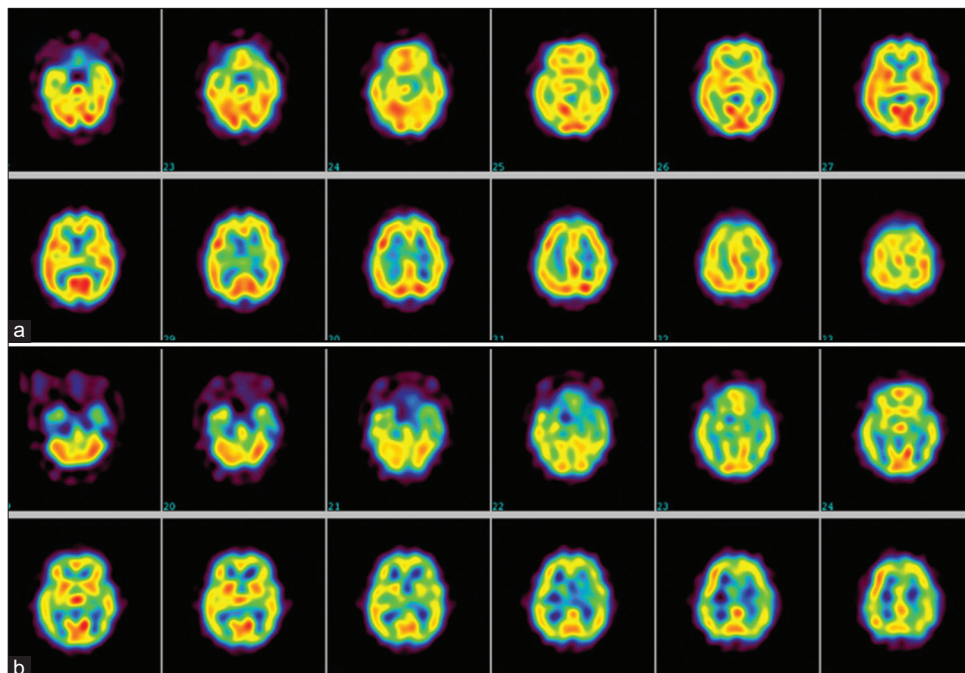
Pre- and post-operative cerebral blood flow (^{123}I -IMP-SPECT), ^{123}I -IMP-SPECT showed reduced cerebral blood flow of extensive bilateral hemispheres from preoperative (a) to 3 months postoperatively (b).
